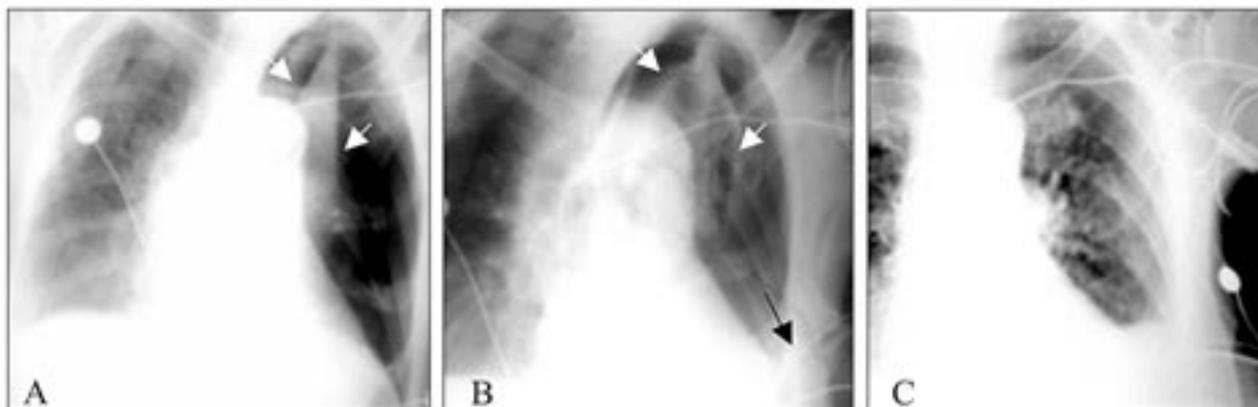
Chest X-rays of the patient. A: Subtotal lung collapse (white arrows). B: After tube placement. The left lung is partially deployed. The tip of the tube is close to the cardiac silhouette (black arrow). C: 12 hours later. Complete left lung deployment and left pleural fluid effusion. The tip of the tube is within the fluid.
